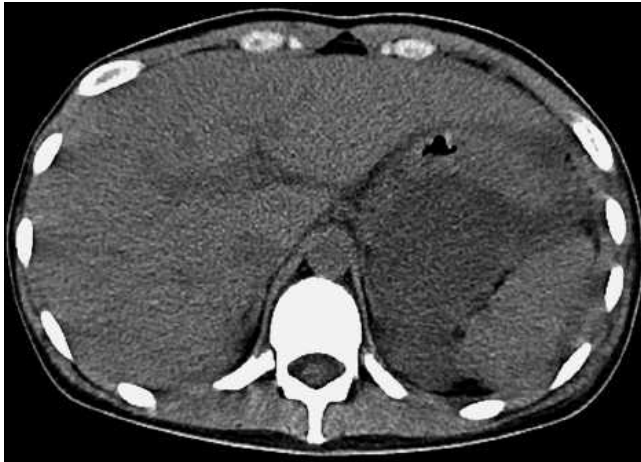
Computed tomography showed a 5-cm omental bursa abscess adjacent to the stomach.
